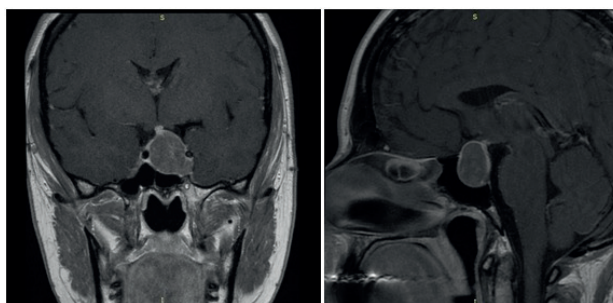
At diagnosis. Pituitary MRI T1-weighted, coronal section. Macroadenoma (19 x 25 x 24 mm) extending upwards into suprasellar region, comes into contact with the optic chiasm and invades left cavernous sinus.
